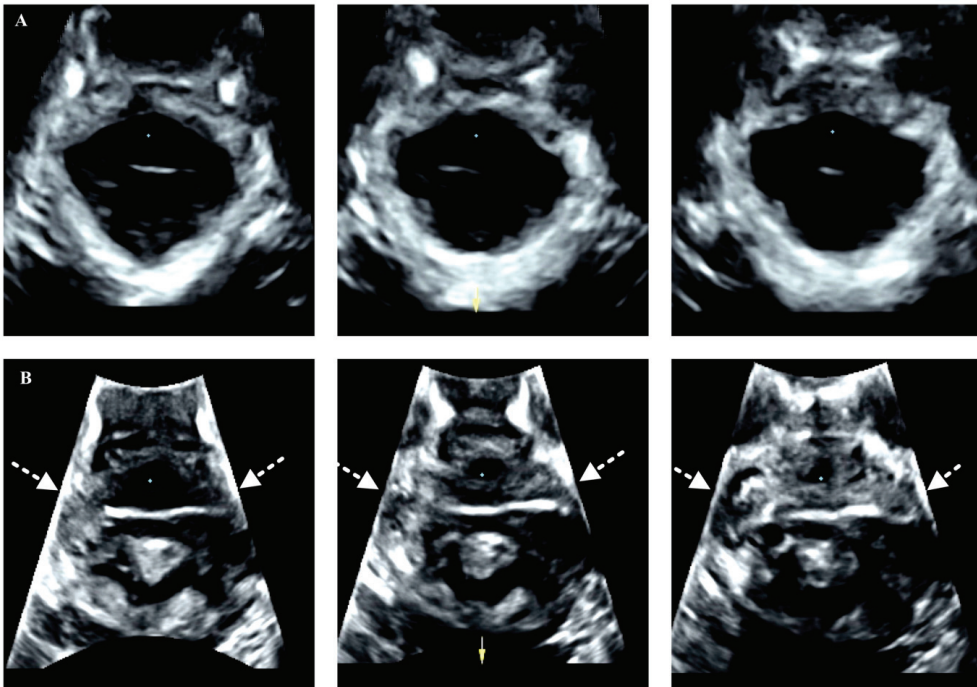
Intact levator ani muscle at the three central slices using tomographic ultrasound imaging: at the level of minimal hiatal dimensions, 2.5 and 5.0 mm above (A).
